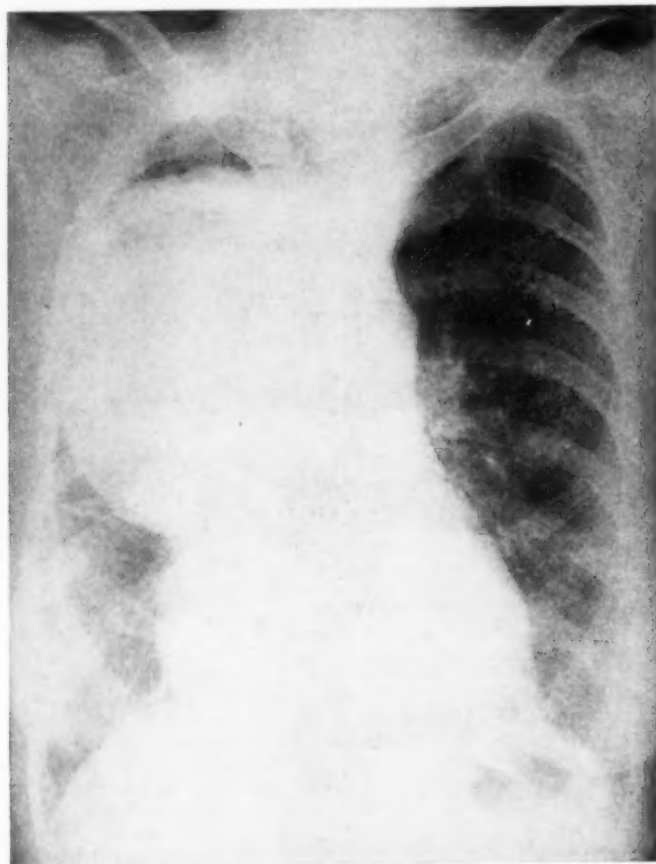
Chest roentgenogram demonstrating the severe degree of esophageal dilatation and tortuosity.
